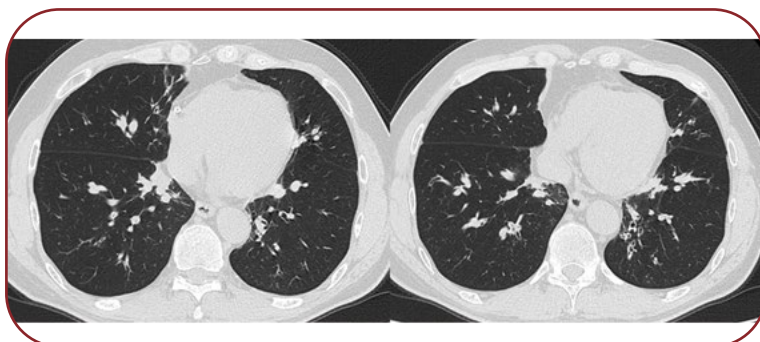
Chest CT scan taken on admission revealed bilateral bronchiectasis and mucoid impactions
